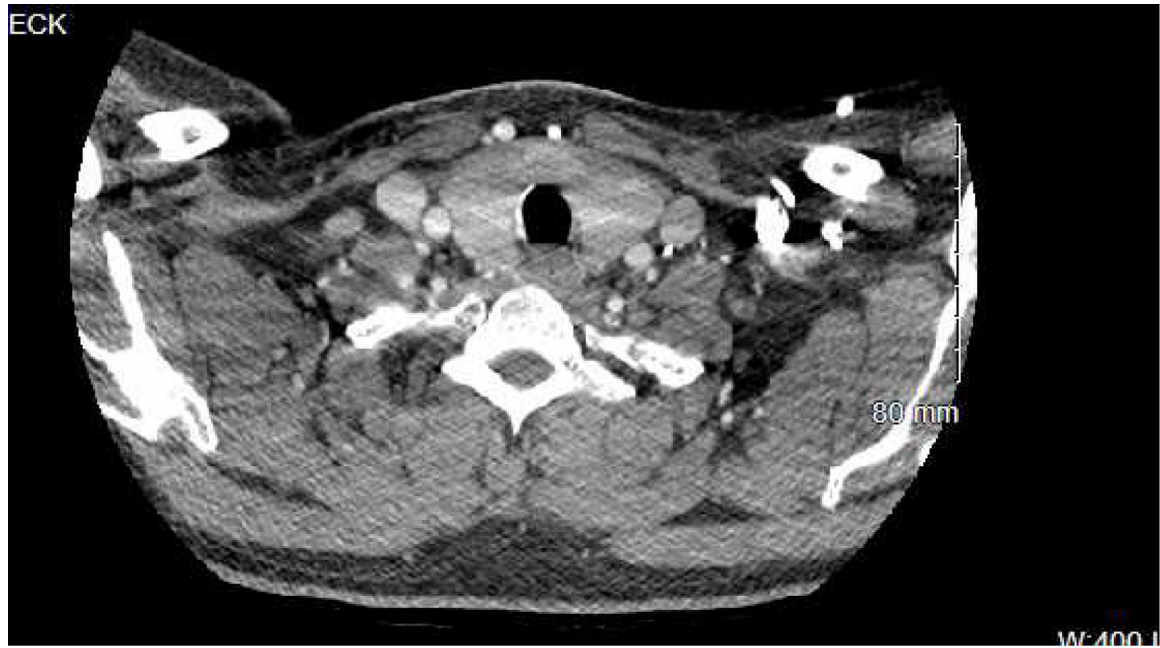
CTA Head and Neck:
